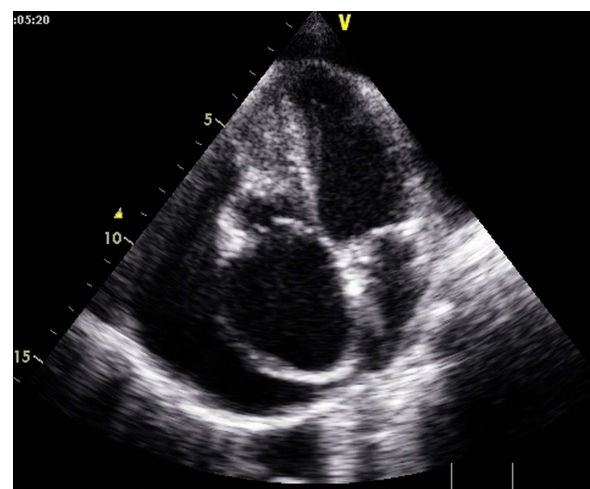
In this echocardiographic image, right atrial dilatation, right ventricular obliteration and marked reduction of the right cavity dimensions with the beginning of apical retraction are easily seen. There is also pericardial effusion.
